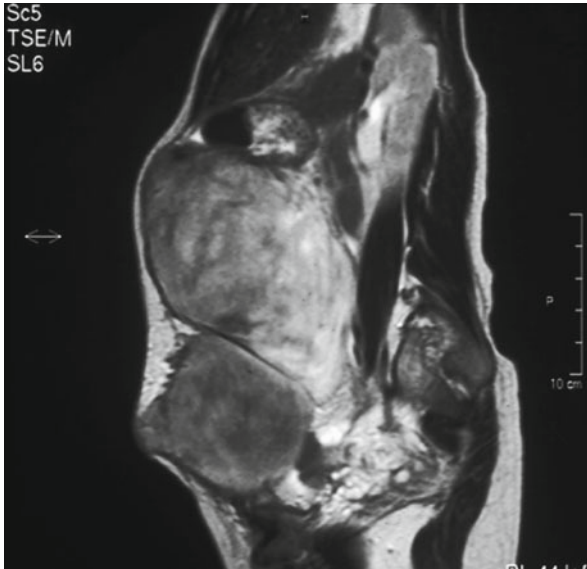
MRI scan showing intra-abdominal desmoid tumor
